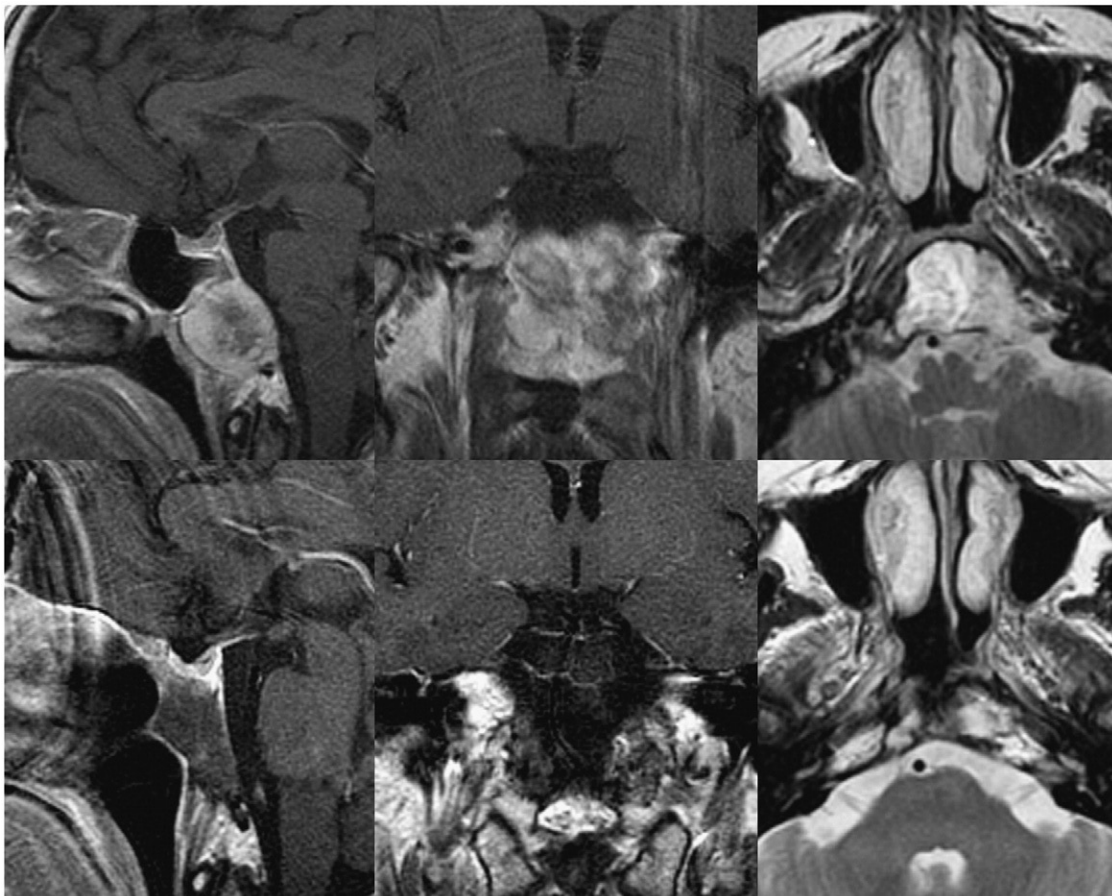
Upper row: preoperative T1 sagittal, coronal MRI with contrast and T2 axial images. Lower row: same sequences 23 months after surgery. Refer to case history 2.
